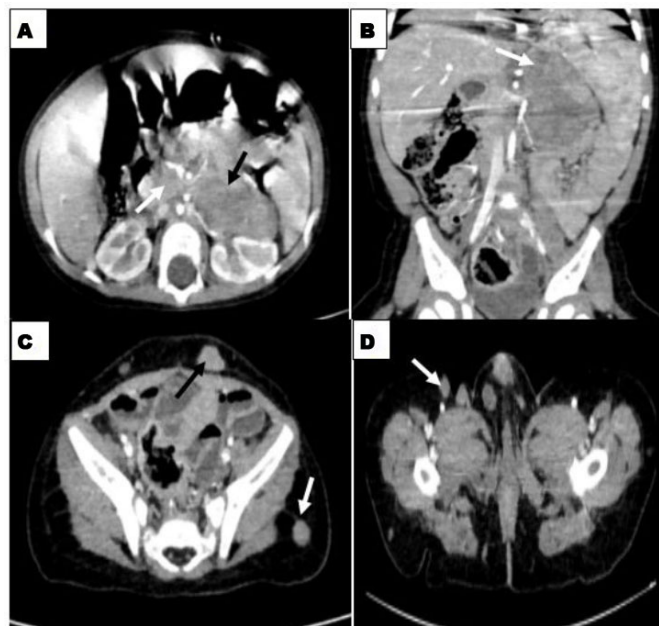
Contrast-enhanced abdominal and pelvic computed tomography: (A) Axial scan shows left retroperitoneal mass, hypodense, heterogeneous, well limited, containing calcifications, enhanced after contrast injection (black arrow), with celiac adenopathy (white arrow). (B) Coronal reconstruction showing left retroperitoneal adrenal process. And hypodense subcutaneous nodules in axial scans, (C) lumbar region (white arrow) and anterior abdominal wall (black arrow), and (D) in inguino-scrotal region (white arrow).
